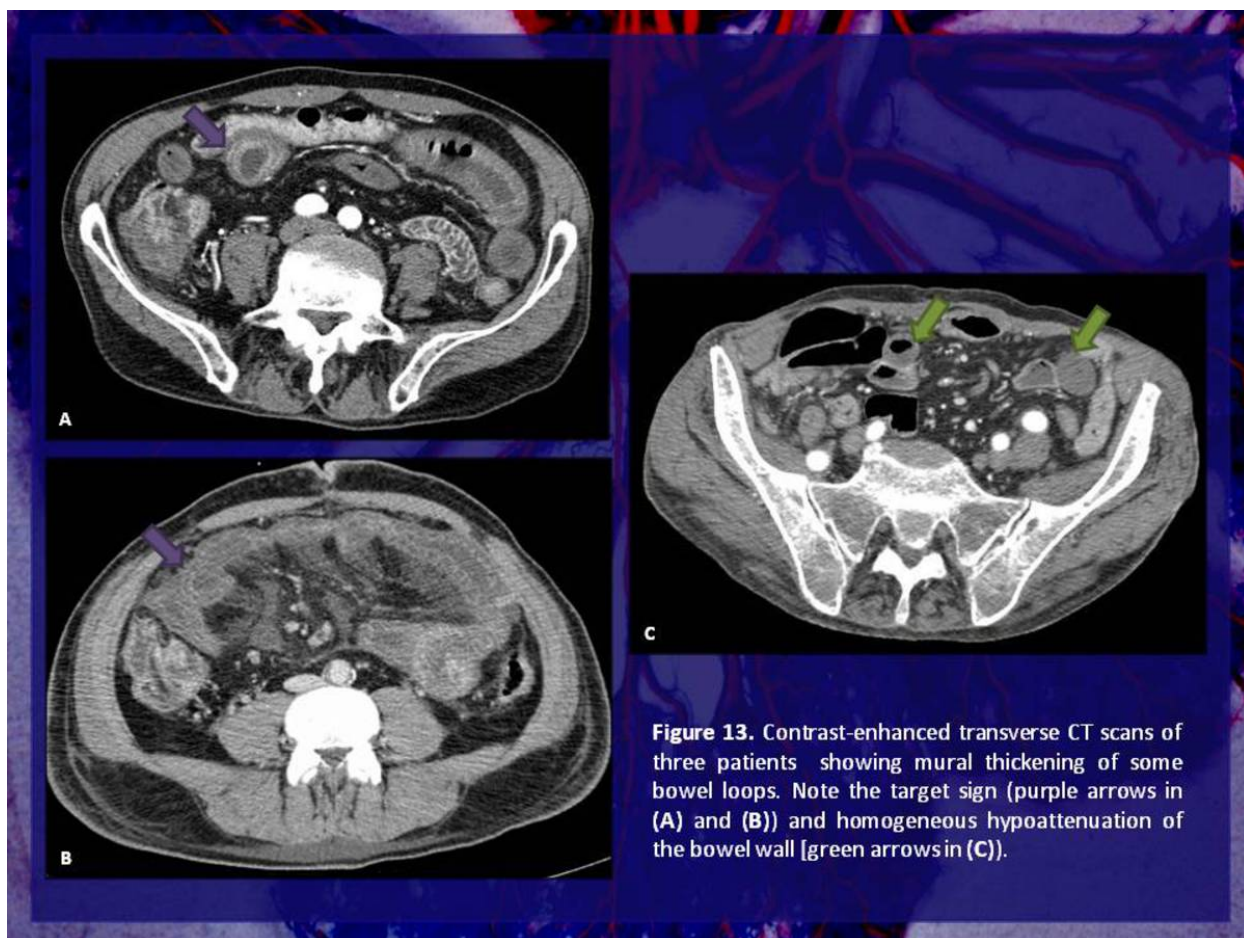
Contrast-enhanced transverse CT scans of three patients showing mural thickening of some bowel loops. Note the target sign (purple arrows in (A) and (B)) and homogeneous hypoattenuation of the bowel wall [green arrows in (C)].
